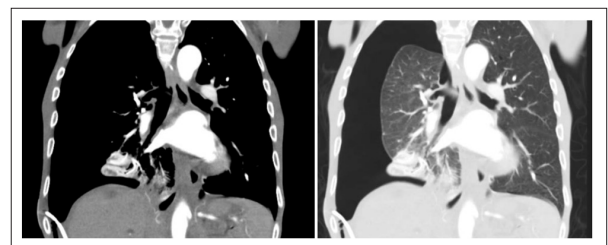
CT showed that the external biliary drain has an abnormal course through the right pleural cavity and the diaphragm into the liver.
